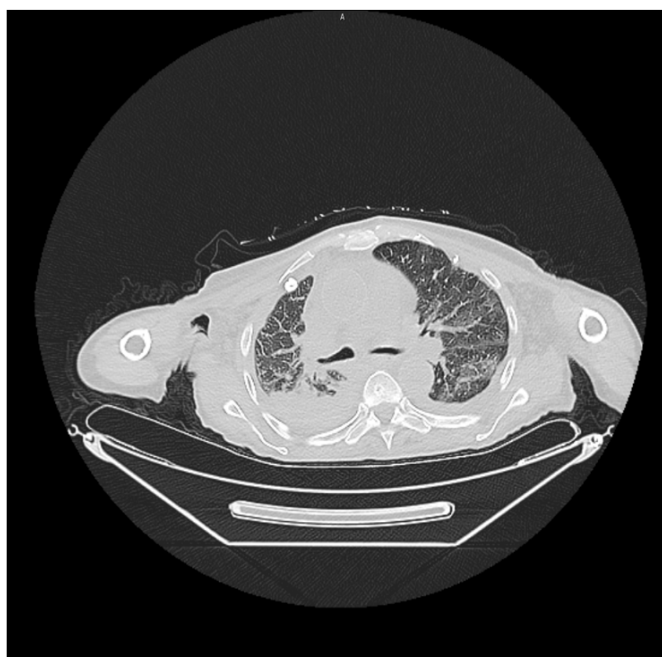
Non-contrast axial chest computed tomography image showing irregular pleural thickening and pleural-based lesions consistent with malignant pleural mesothelioma
